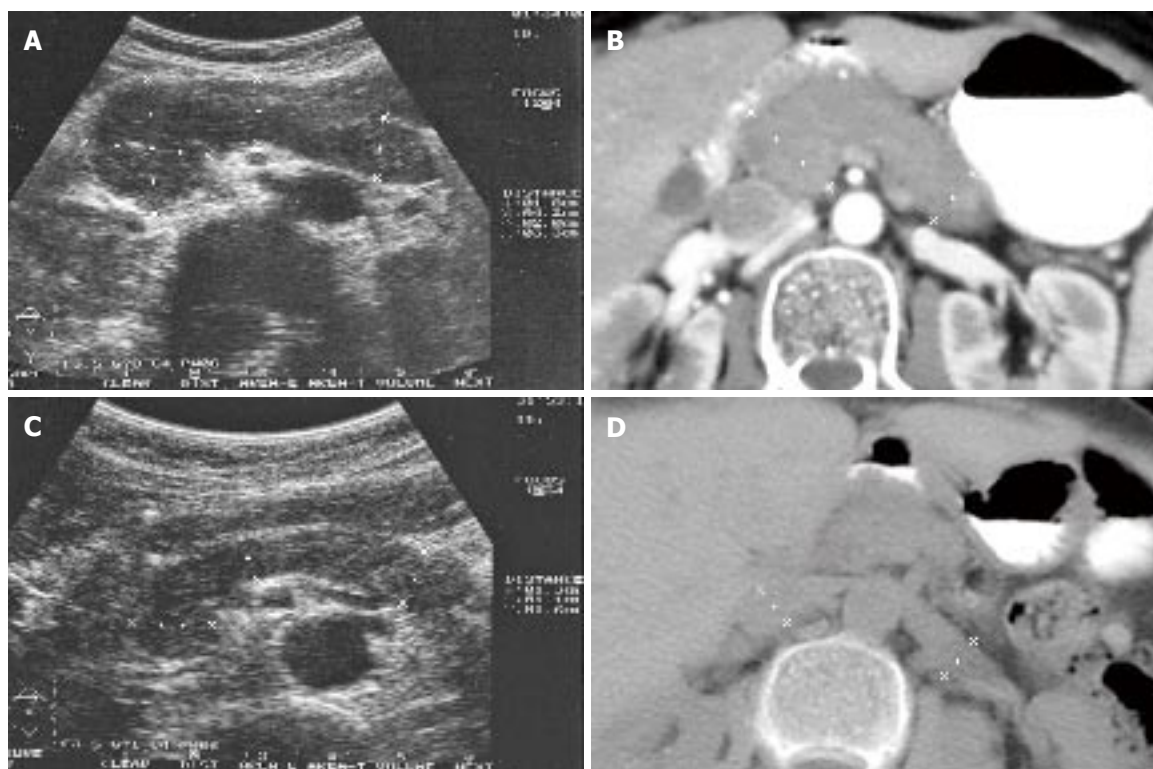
Abdominal ultrasonography (A) and CT (B) revealed a diffusely enlarged pancreas with sharp margins similar to sausage appearance. Four weeks after the steroid therapy the size of the pancreas became normal (C and D).
